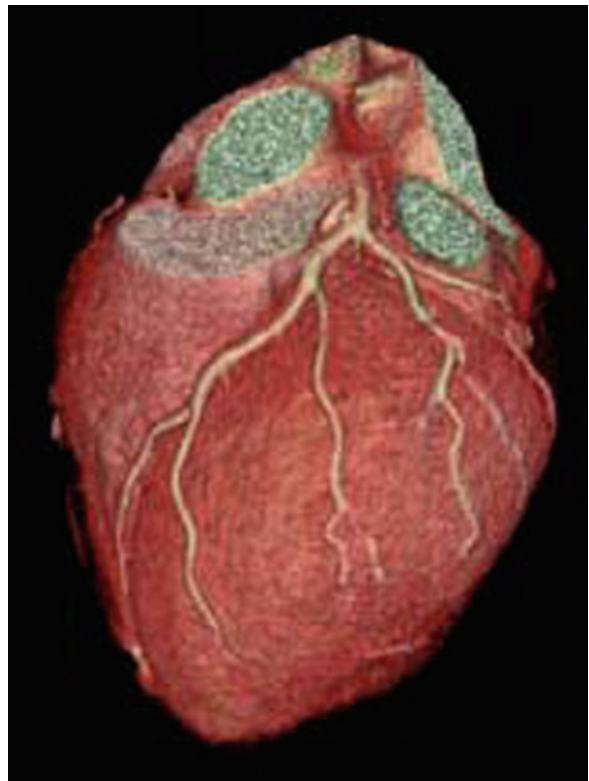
A cardiac CT study may be volume rendered by assigning colors and transparencies to the Hounsfield units within it, and then reproducing the effect of light being transmitted and reflected from it. In this case, sophisticated segmentation and additional user interaction must be used to eliminate noncardiac structures from the CT prior to 3D rendering
